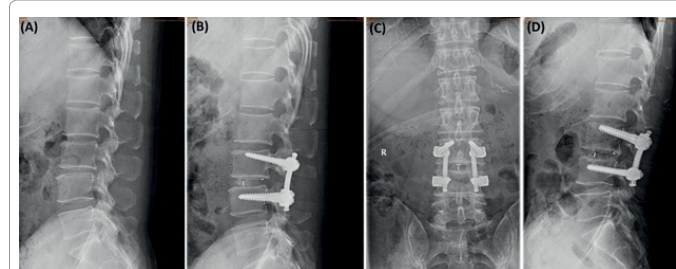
Surgical reduction and PLIF performed in a 42-year-old woman with isthmic spondylolisthesis. (A) Preoperative lateral X-ray (B) Immediate postoperative lateral X-ray showed that complete reduction of the spondylolisthesis (C) 10 months and (D) 17 month's follow-ups radiographs show significant correction in compare to pre-operative lateral radiograph.
